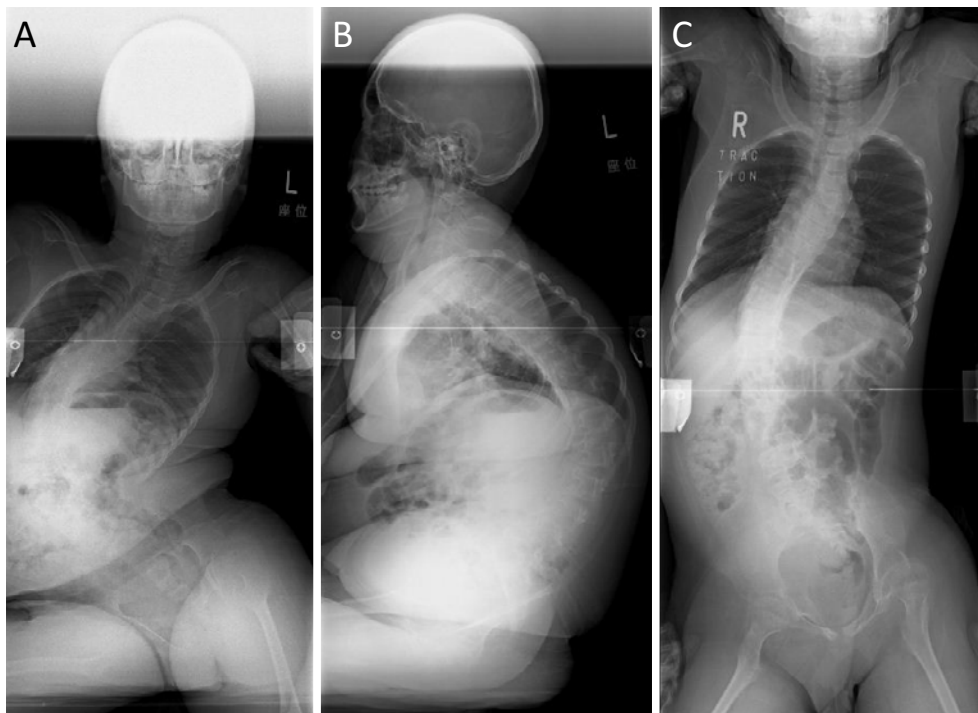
Preoperative X-ray images of a representative case of scoliosis secondary to spinal muscular atrophy (SMA). Frontal (A) and lateral view (B) with the 12-year-old patient sitting and frontal view while supine in traction (C). Preoperative Cobb angles were 115° while the boy was sitting and 60° while the patient was in traction and supine.
